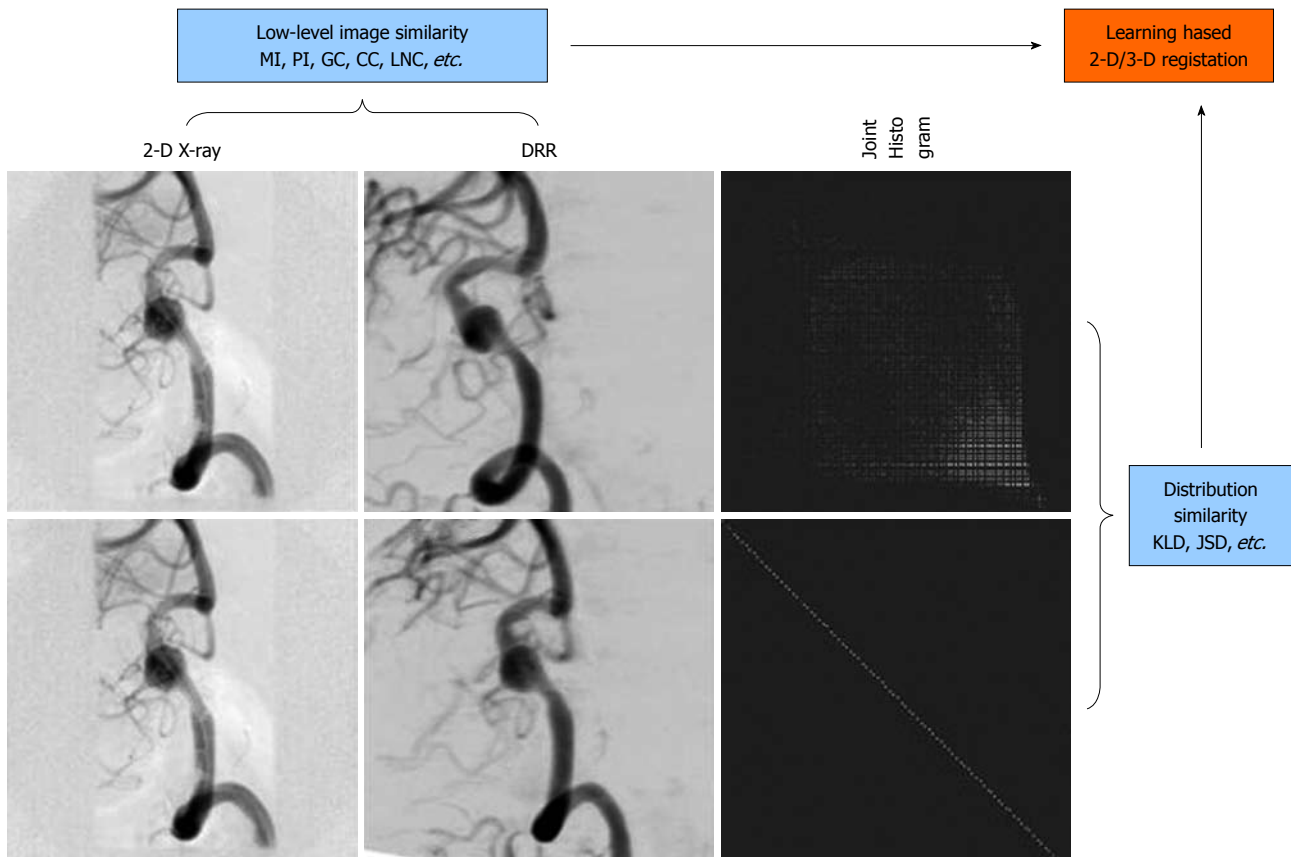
Learning-based 2-D/3-D registration^[33]. DRR: Digitally reconstructed radiograph.
